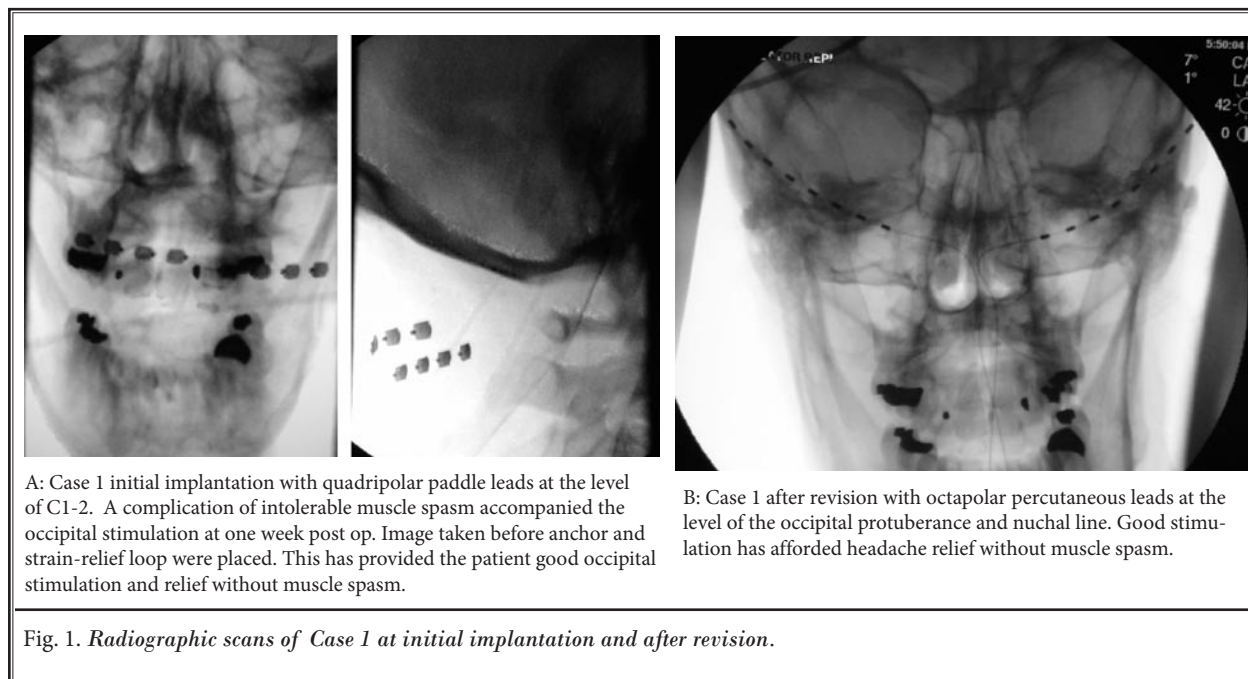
Radiographic scans of Case 1 at initial implantation and after revision.
